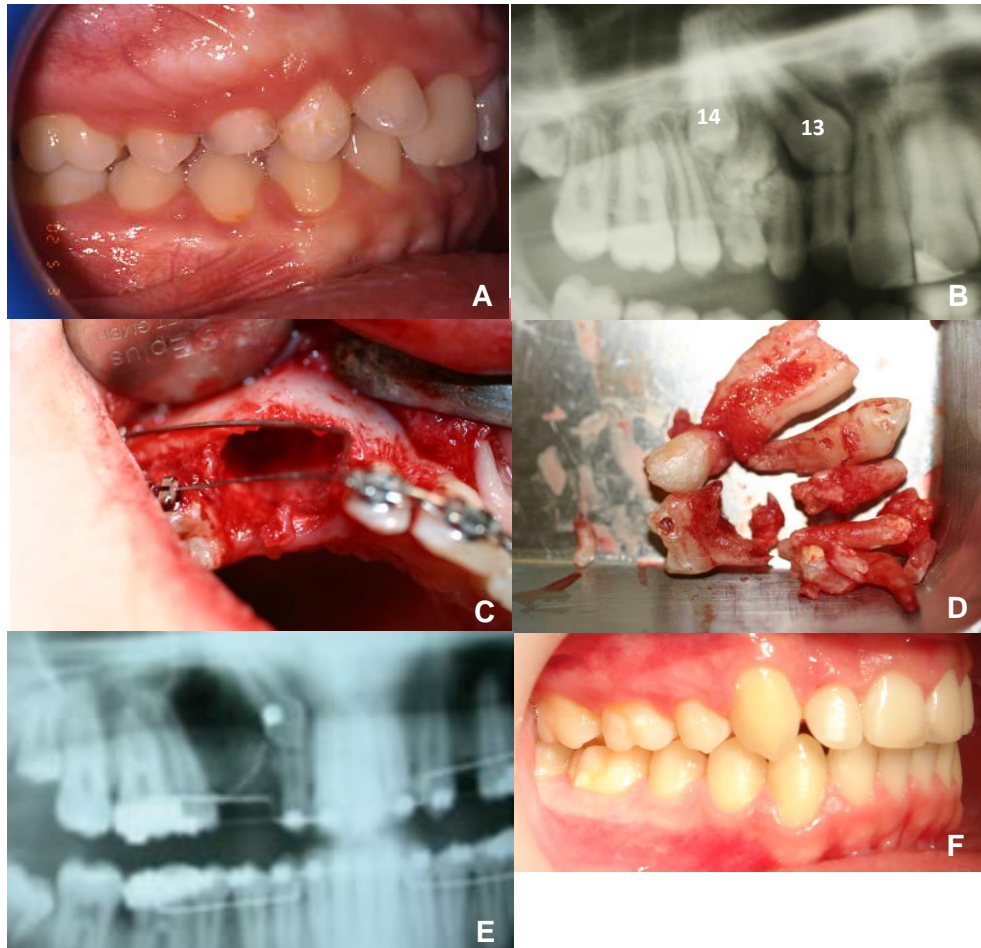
A male patient of FMUP with 13 impacted and odontoma. A) Right intra-oral view; B) Radiographic view, where are visible the odontoma, 14 and 13 impacted; C) and D) removal surgery of odontoma and the teeth 14; F) traction of the teeth 13 and F) final result of the treatment.
